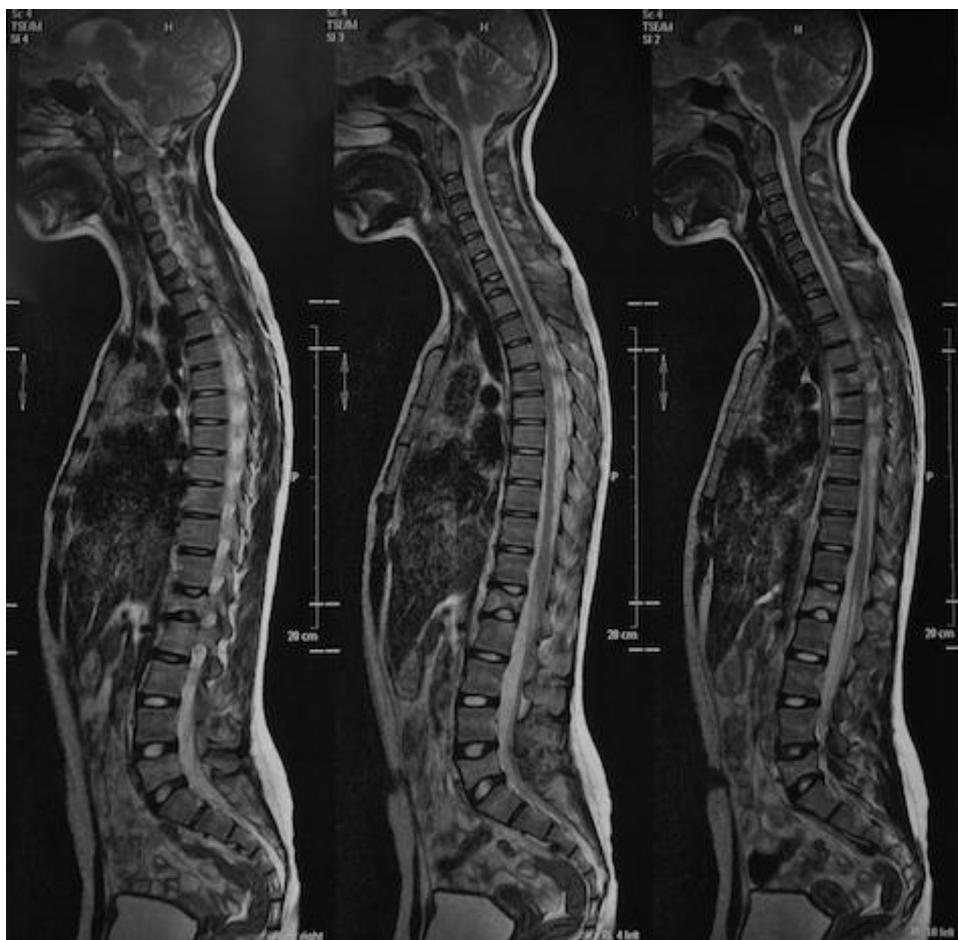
Whole spine sagittal magnetic resonance imaging (T2) showed C2, T1, T5, T12, and L4 vertebral body destruction without compression of spinal cord.
